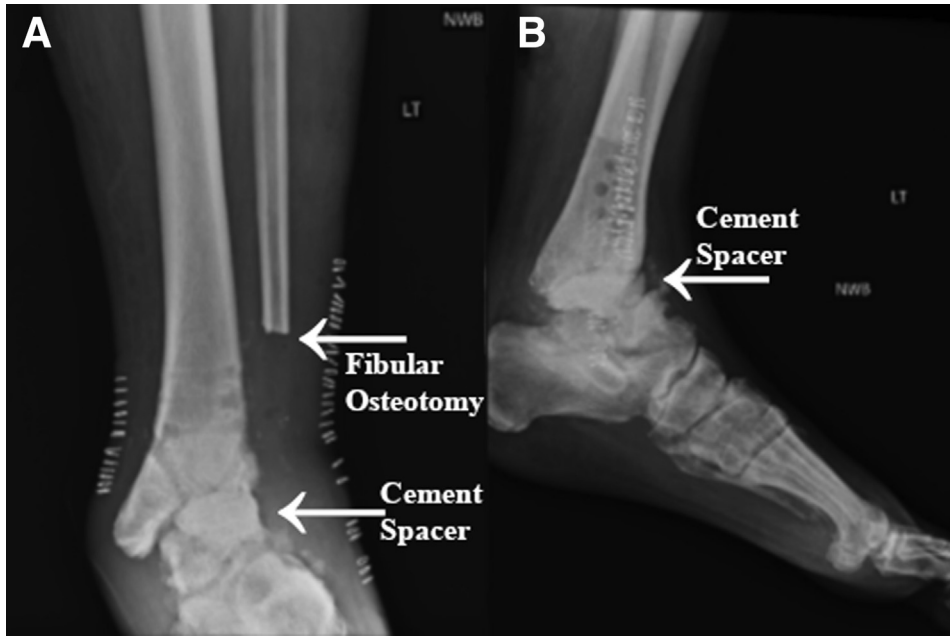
(A, B) Preoperative antero posterior and lateral non-weight-bearing radiographic views of the left ankle following a previous procedure consisting of removal of hardware, bony exostectomy, fibular osteotomy of the distal portion of the fibula with irrigation and debridement, biopsy, culture, and placement of a cement spacer.
